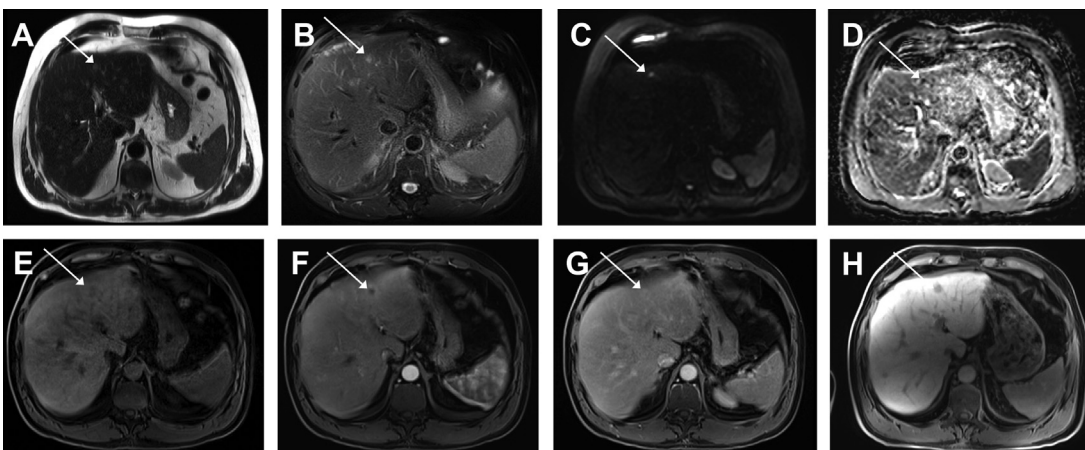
Hepatic granuloma mimicking metastasis. Tiny lesion, hyperintense on T2 HASTE (A), better appreciated on fat-saturated T2-weighted images (B), hyperintense on diffusion (C) with restriction (D), hypointense on fat-saturated T1-weighted images (E), with rim hyperenhancement in the arterial phase (F), progressive peripheral filling in the delayed phase (G) and no uptake in the hepatobiliary phase (H). Given that the patient had several similar lesions within the liver, it was mistaken for metastasis, with a final diagnosis of hepatic granuloma based on the pathologic findings.
